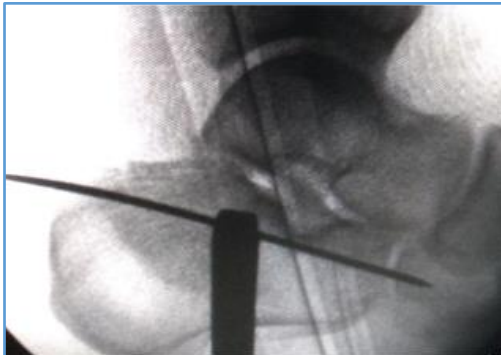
X-ray of the Subchondral K-Wire Passed to the Cuboid to Maintain the Articular Reduction
